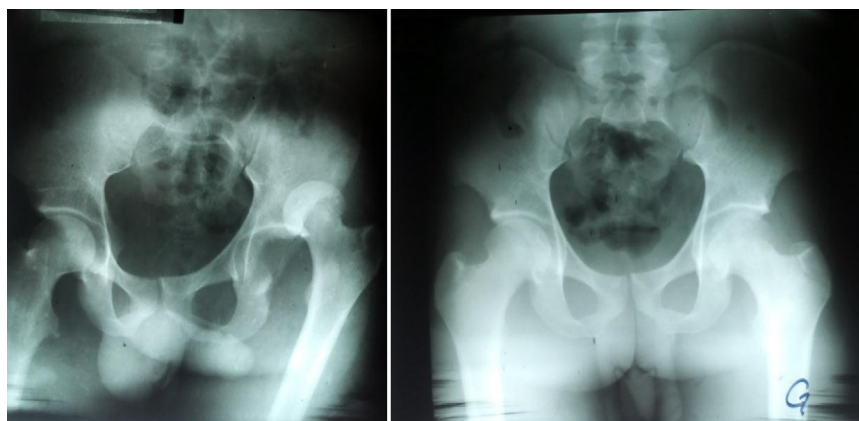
X-rays of a posterior dislocation before and after reduction.
